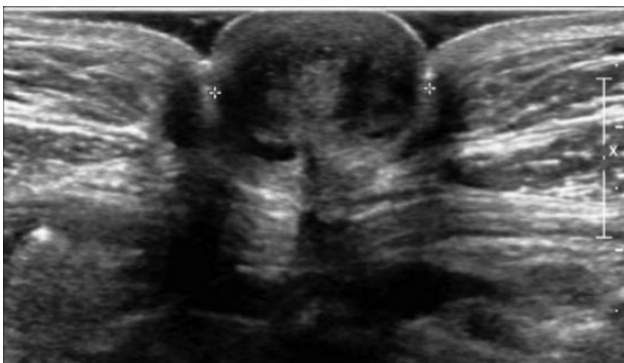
Ultrasonography of the umbilicus demonstrated a hypodense nodule of 1.8 cm in the umbilicus.
